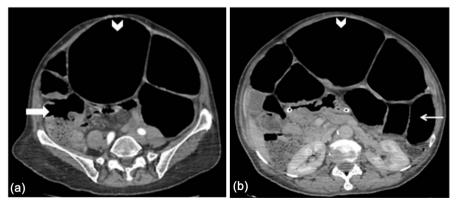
Abdominal CT in axials sections, showing an important dilatation of the ascending colon (thick arrow), transverse colon (arrowhead) and descending colon (thin arrows). The colonic wall is thin without any abnormality of enhancement. Absence of ascites.
